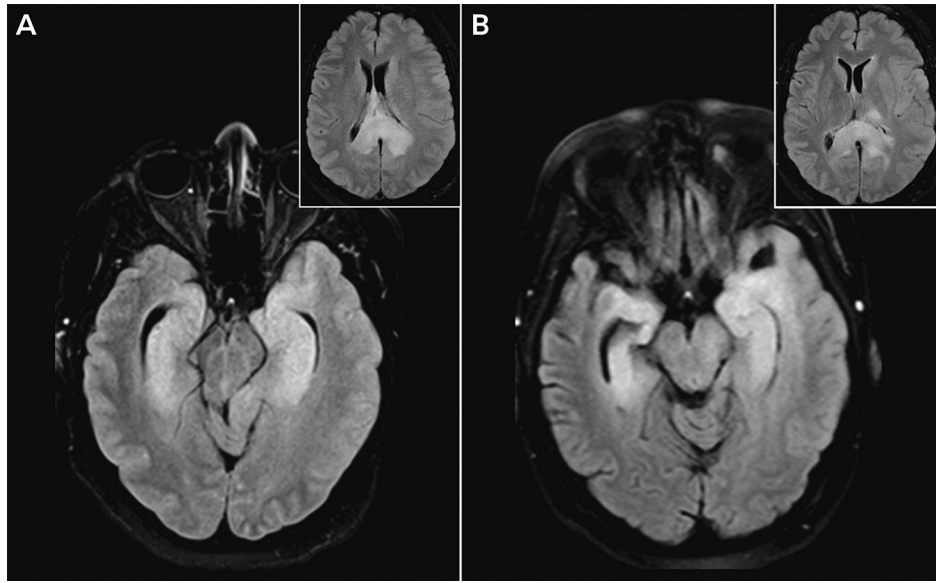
Imaging of the patient in CASE 13-4. Axial fluid-attenuated inversion recovery (FLAIR) images show bilateral temporal lobe and corpus callosal lesions (*insets*) at presentation (*A*) and 10 days later following empiric immunosuppressant treatment (*B*).
